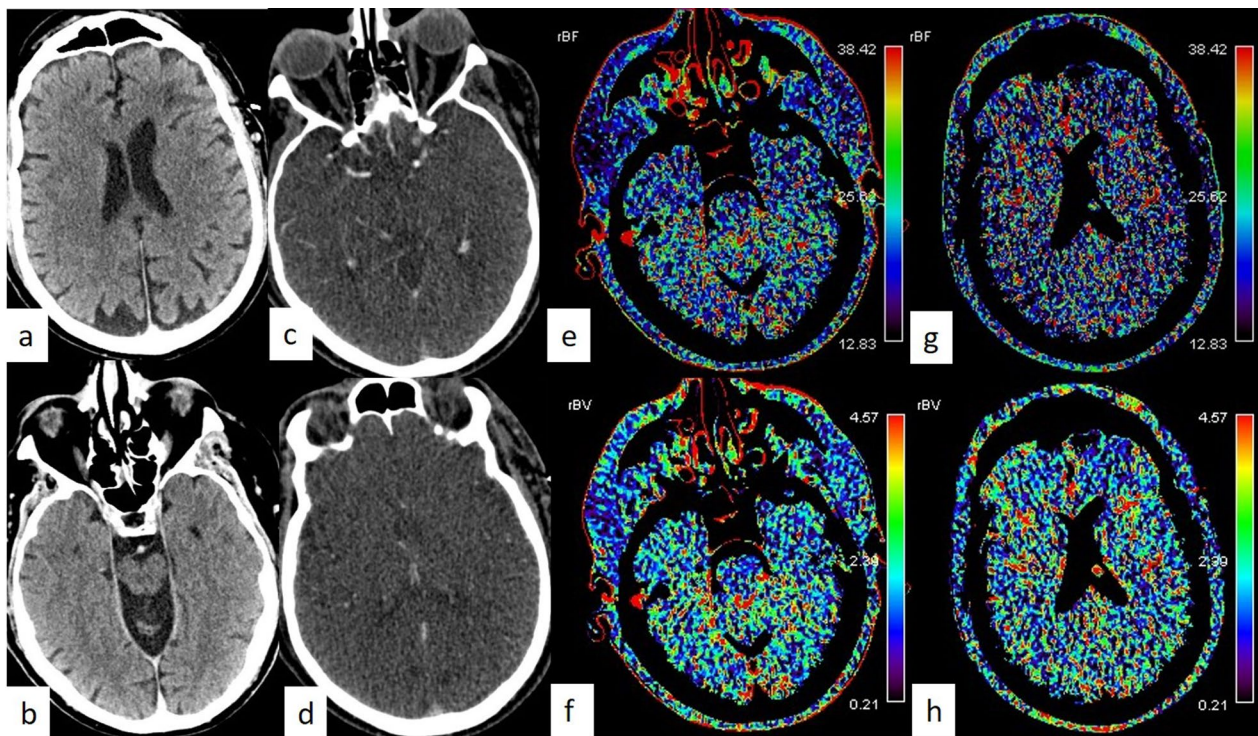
Non-contrast CT images for a comatose cardiac arrest patient in his 70 s demonstrated preserved grey-white matter differentiation (a and b). CT angiography revealed preserved filling of the distal branches of anterior, middle, and posterior cerebral arteries (c and d) as well as opacification of the internal cerebral veins (d). Coloured perfusion maps indicate severely reduced or absent cerebral blood flow (e and g) and cerebral blood volume (f and h) in the brainstem, consistent with CT perfusion features of non-survival brain injury
